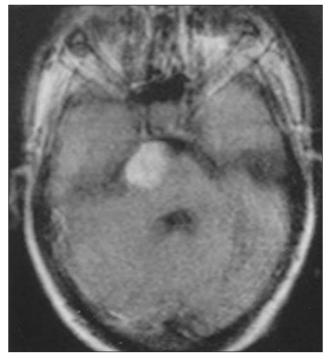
Preop. MRI showing the mass in the left PCA
